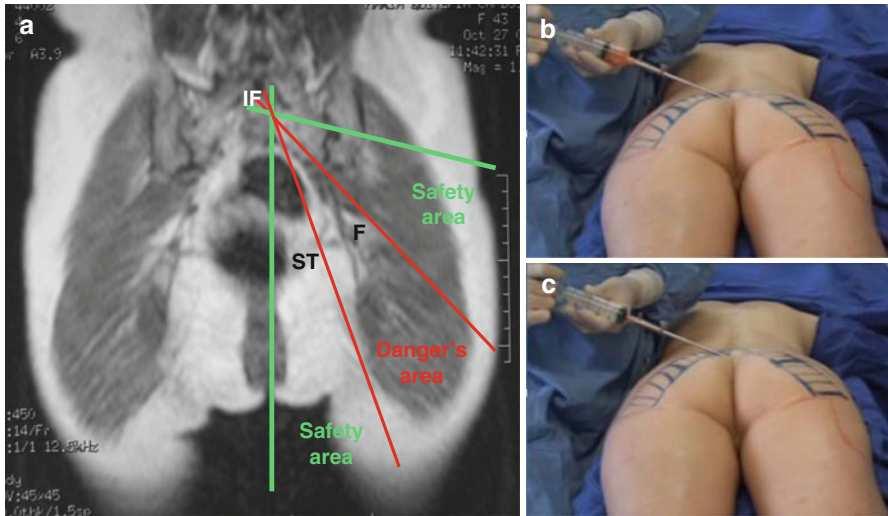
Coronal view of gluteus magnetic resonance image (a) with anatomical landmarks to determine two safety triangles (green) and one danger triangle (red): 1 cm below the beginning of the intergluteus fold (*SI*), the beginning of the natural Intergluteal fold (*IF*), ischial tuberosity osseous skin projection (*TI*), and head femoral osseous skin projection (*F*). During the submuscular lipograft injection in the gluteus, (b) the lateral safety area was filled with careful retro-injection technique without pressing with a number 5 cannula to an adequate distribution of the fat into the muscle. The submuscular lipograft technique was finished (c) and the subcutaneous lipograft in the danger triangle will be started
